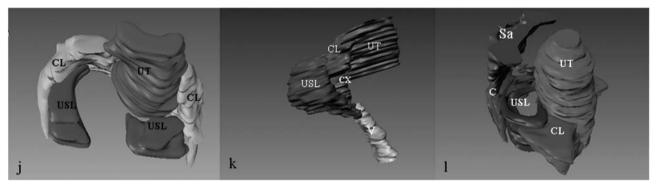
Uterine prolapsed women MRI 3D models. Panel j, from above behind observe the USL " \vee ", the left detachment from the cervix. Panel j, from right side observe the right USL insert into vaginal. Panel k, from right side observe the relation between the right USL and coccyx. UT=uterus, CX=cervix, R=rectum, Sa=sacrum, C=coccyx, CL=cardinal ligament, USL=uterosacral ligament.
